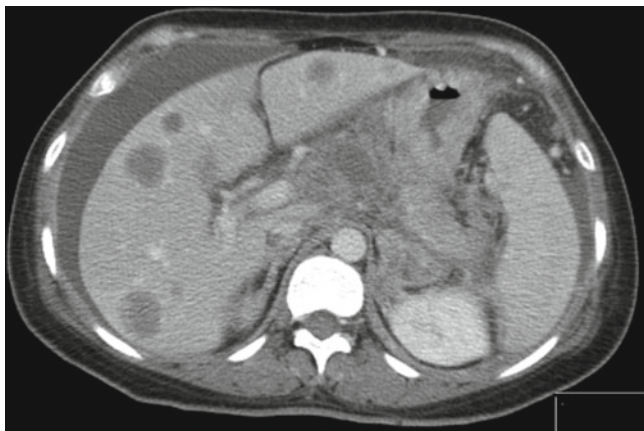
Characteristic CT appearance of liver metastases from colorectal carcinoma
